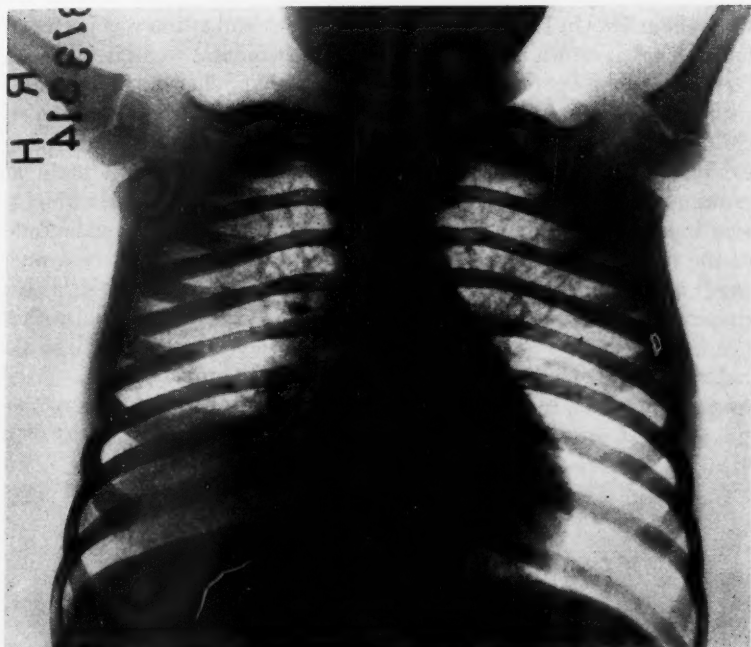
Roentgenogram showing lung abscess in lower lobe of right lung.
